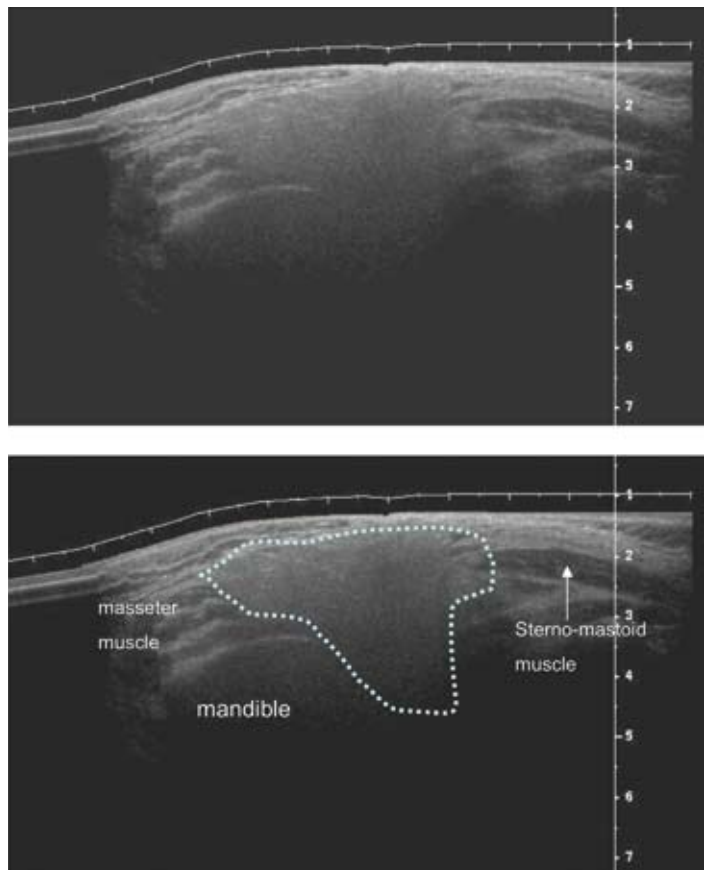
Ultrasound image showing normal appearance of parotid gland outlined by dotted line.
